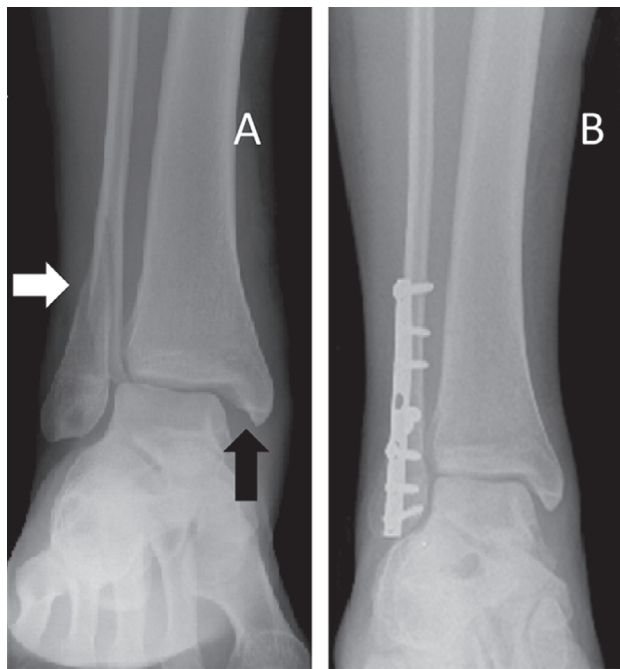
Radiographs of a bimalleolar equivalent ankle fracture. This fracture can also be classified as a Weber type B fracture or supination-external rotation fracture according to Lauge-Hansen. (A) Radiographs taken after injury. The white arrow demonstrates the fracture of the lateral malleolus. The black arrow demonstrates medial mortise widening consistent with deltoid and syndesmosis ligament injury. (B) Postoperative x-rays. This patient required only fixation of the lateral malleolus because there was enough ligamentous intactness to keep the joint stable after lateral fixation alone.
